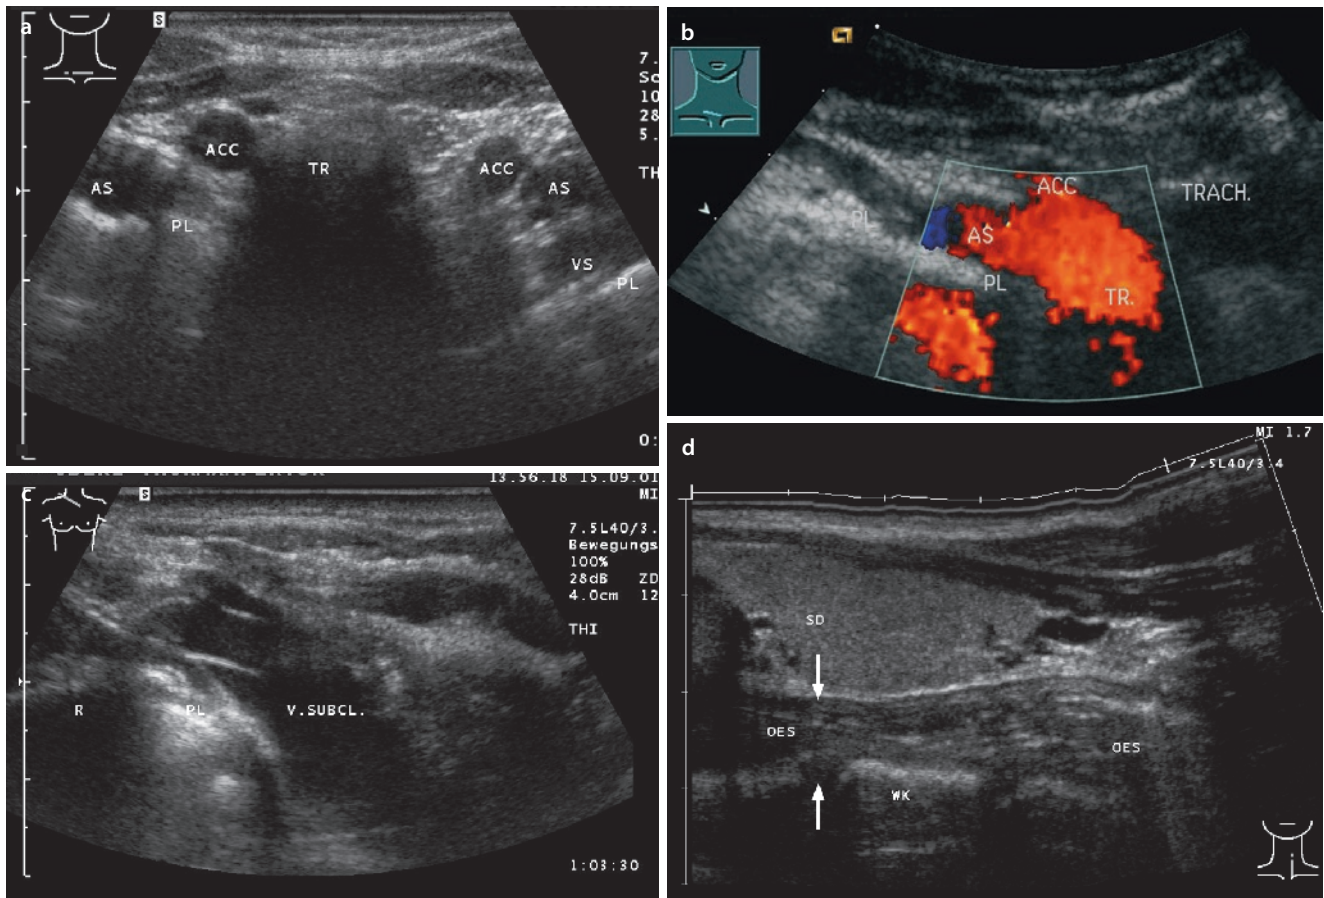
Suprasternal examination. Supraaortic vessels. a The suprasternal transverse section demonstrates the cross section of the supraaortic vessels, right, distal to the branching of the brachiocephalic trunk. ACC common carotid artery, AS subclavian artery, VS subclavian vein, TR trachea, PL pleura/pulmonary reflex. b Half-sagittal right-hand section. The brachiocephalic trunk (TR) is shown by color-Doppler sonography, branching into the subclavian artery (AS) and the common carotid artery (ACC). The paratracheal region with its lymph nodes can be seen dorsal to the trunk in this section. Lateral to the reflex of the pleura/lung (PL), there is a mirror
